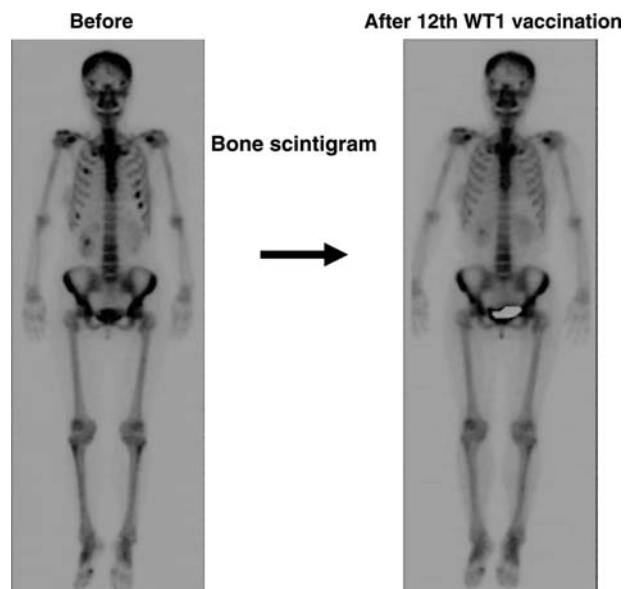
Improvement of bone lesions. Bone scintigram of the same patient with multiple myeloma showed that WT1 vaccination improved bone lesions especially in ribs.
